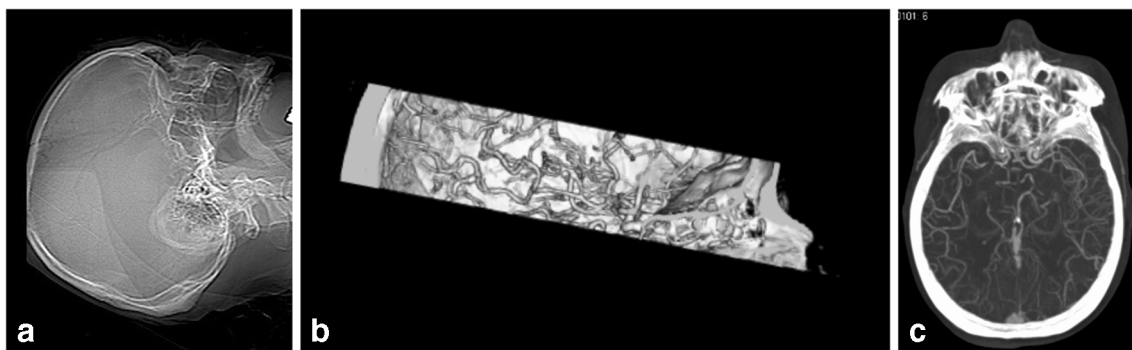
a A computed tomography (CT) scout image. Acquisition was started from the line (inferior white line) connecting the pituitary fossa (black dot) with the point (white circle) 2 cm upward from the internal occipital protuberance (black arrow) by tilting the gantry (broad white arrow). CT scanning was performed with 4-cm coverage (dashed arrows).
